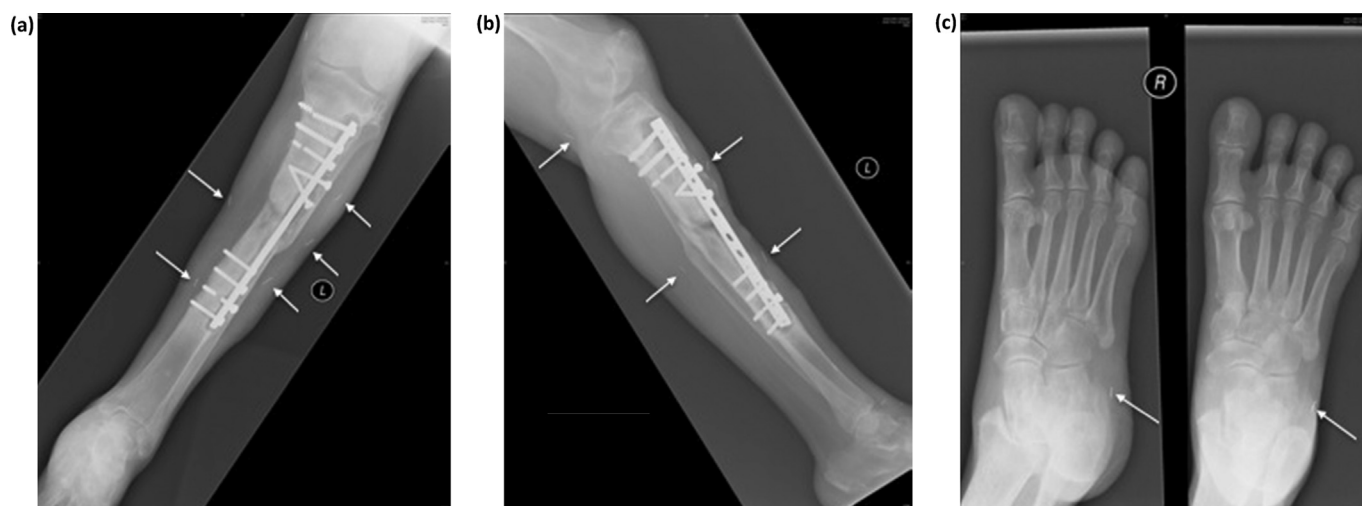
(a) Antero-posterior radiograph of the left leg. (b) Lateral radiograph of the left leg. (c) Oblique and antero-posterior radiograph of the right foot.
